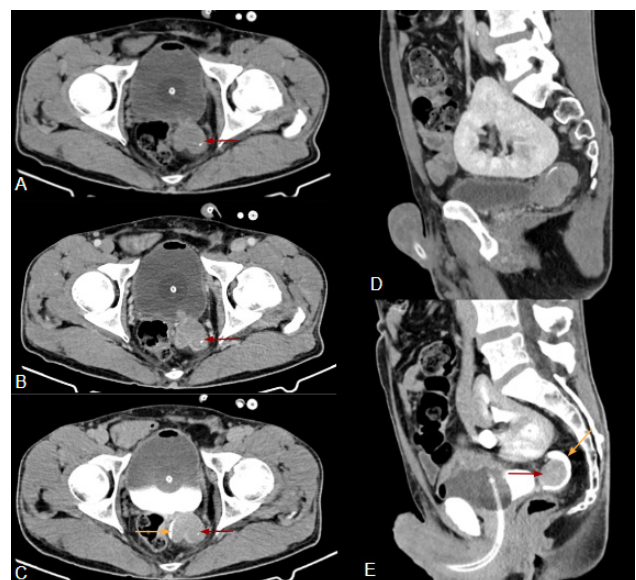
Pelvic CT axial (A - without contrast, B - venous phase, C - excretory phase) and sagittal (D - venous phase, E - excretory phase) images showing a solid contrast-enhancing lesion located within a bladder diverticulum adjacent to the left ureterovesical junction (red arrows), with a few internal calcifications. This lesion can be seen displacing the ureter posteriorly and medially (orange arrow). In the sagittal images (D and E), a pelvic kidney can also be seen.
